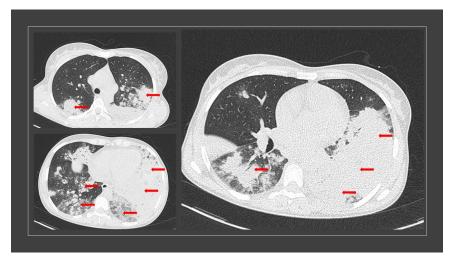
Chest CT-scan showing bilateral ground glass opacities with crazy paving, indicating severe CVOID-19 disease. Red arrows pointing to the extent of involvement.
